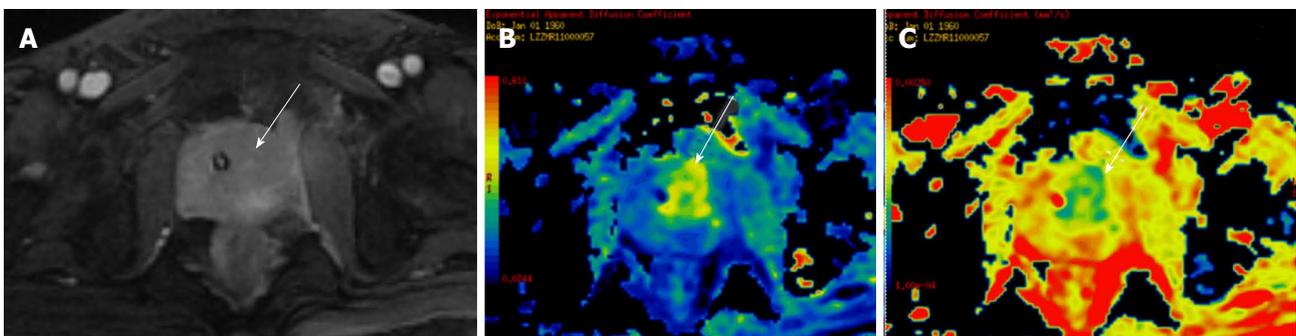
A 65-year-old male presented with symptoms of bladder outlet obstruction and raised serum PSA. DCE-MRI revealed a focal lesion in the central gland on the left side (white arrow in A), with restricted diffusion (white arrow in B) and low ADC values (white arrow in C) suggestive of malignancy. Biopsy revealed prostatic adenocarcinoma. ADC: Apparent diffusion coefficient; MRI: Magnetic resonance imaging.
